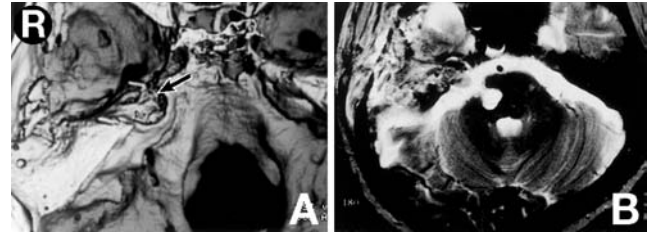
(A) Postoperative three-dimensional computed tomography scan indicating the extent of drilling of the petrous apex (arrow). (B) Postoperative T₂-weighted magnetic resonance image showing total removal of the hematoma and angioma.
